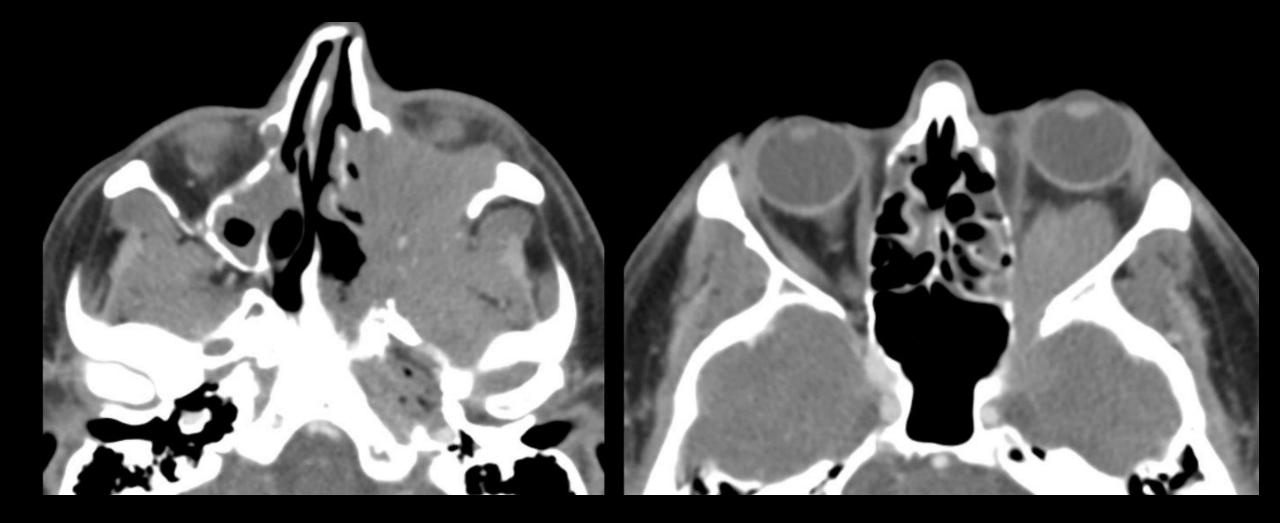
Axial post-contrast CT at the level of the maxillary sinuses and orbits demonstrating left maxillary sinus soft tissue mass infiltrating the masticator space and left orbit, including the apex.
